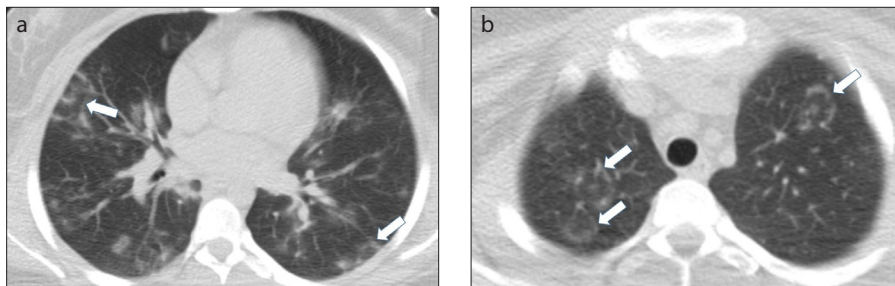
a, b. Axial thorax CT images (a, b) show round and crescentic infiltrations with or without a centrilobular dot (white arrows), which corresponds to target-shaped combined halo and reversed-halo sign.
